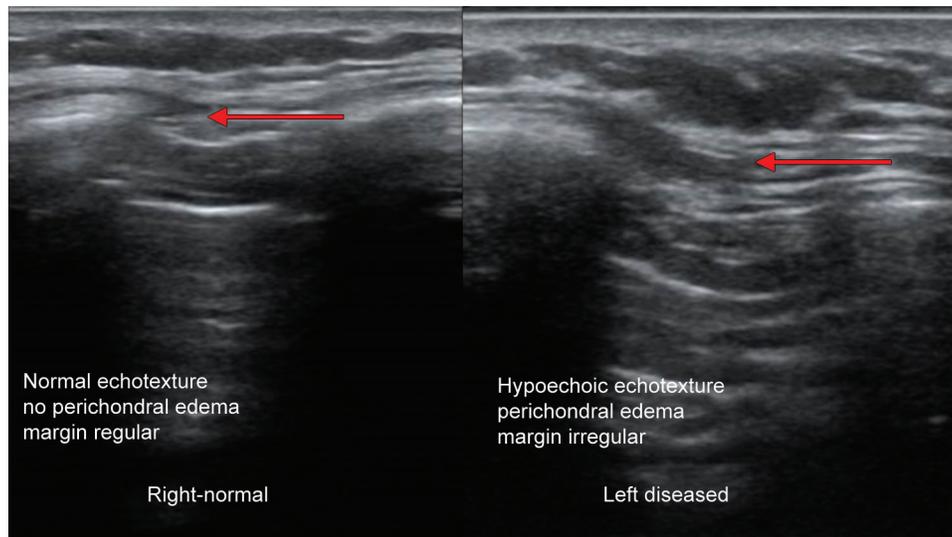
Ultrasound evaluation of the 10th rib at the most tender point and comparison with the contralateral side
